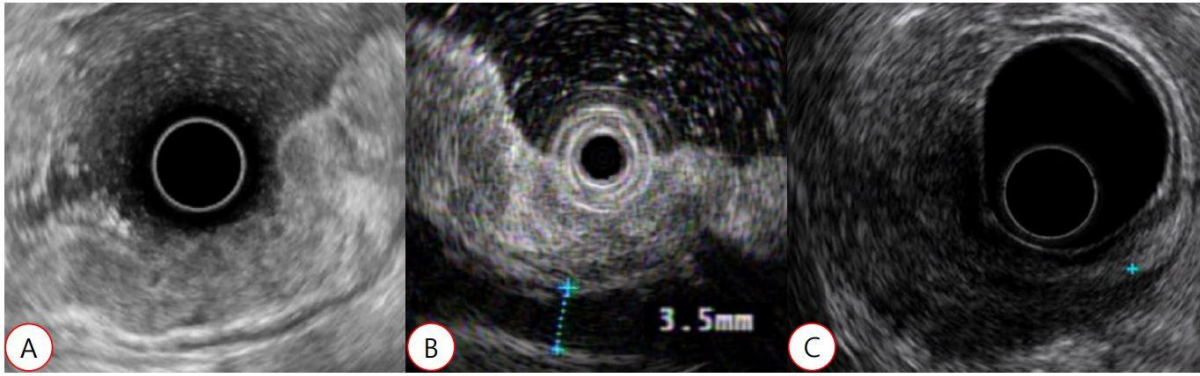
Endoscopic ultrasonographic images of patients diagnosed with hypertrophic gastritis (A), advanced gastric cancer with preserved wall layer (B), and with destroyed wall layer (C).
